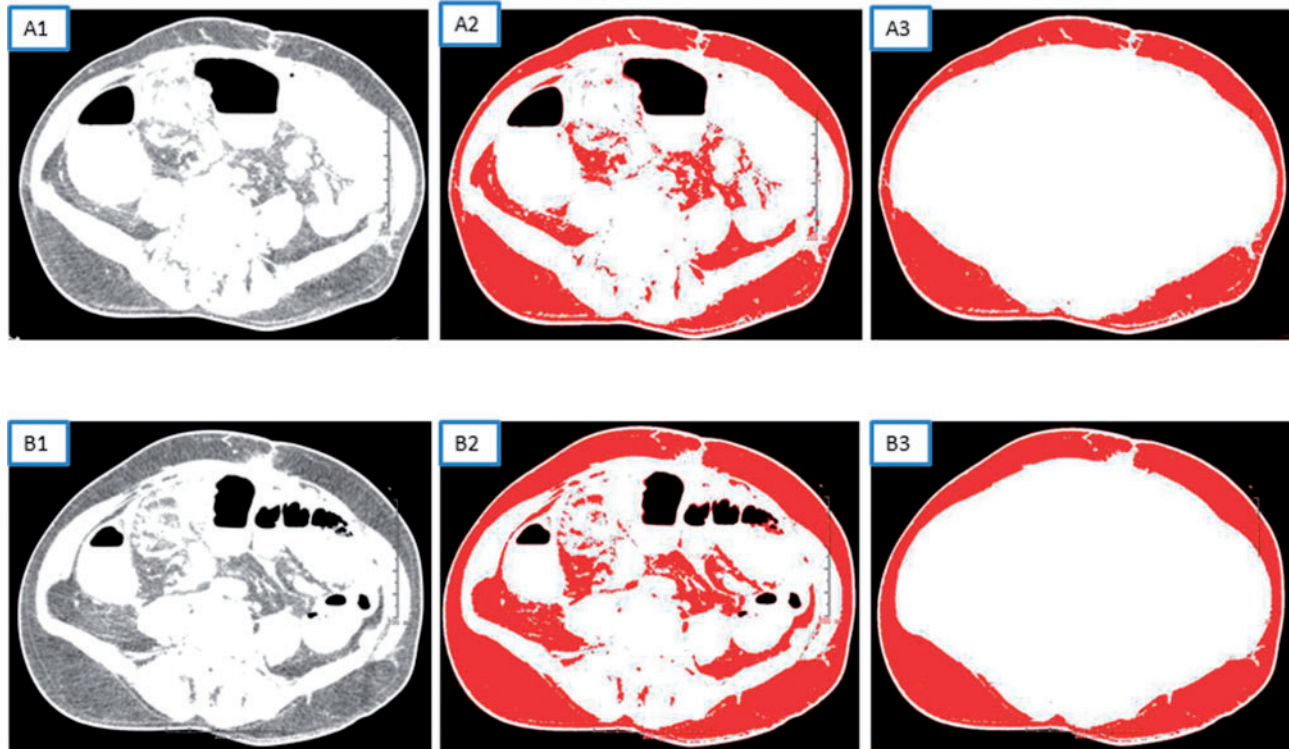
CT measurement of visceral fat area (VFA) and subcutaneous fat area (SFA). Original transverse CT images at the level of L3 (the first CT, A1; the latest CT, B1). Total fat tissue was extracted from the original image (the first CT, A2; the latest CT, B2). SFA was extracted from the original image (the first CT, A3; the latest CT, B3).
